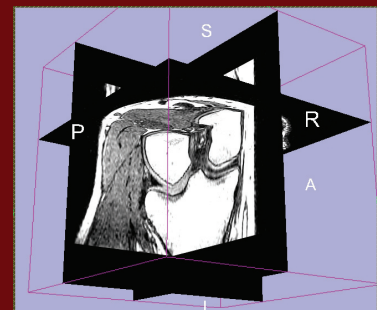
Magnetic resonance images of the three planes of the knee.
